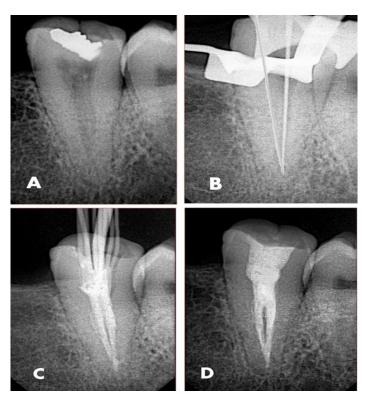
(A) pre-operative diagnostic radiograph showing permanent mandibular right second molar.(B) Working length determination. (C) Master cone selection. (D) Post-obturation radiograph
